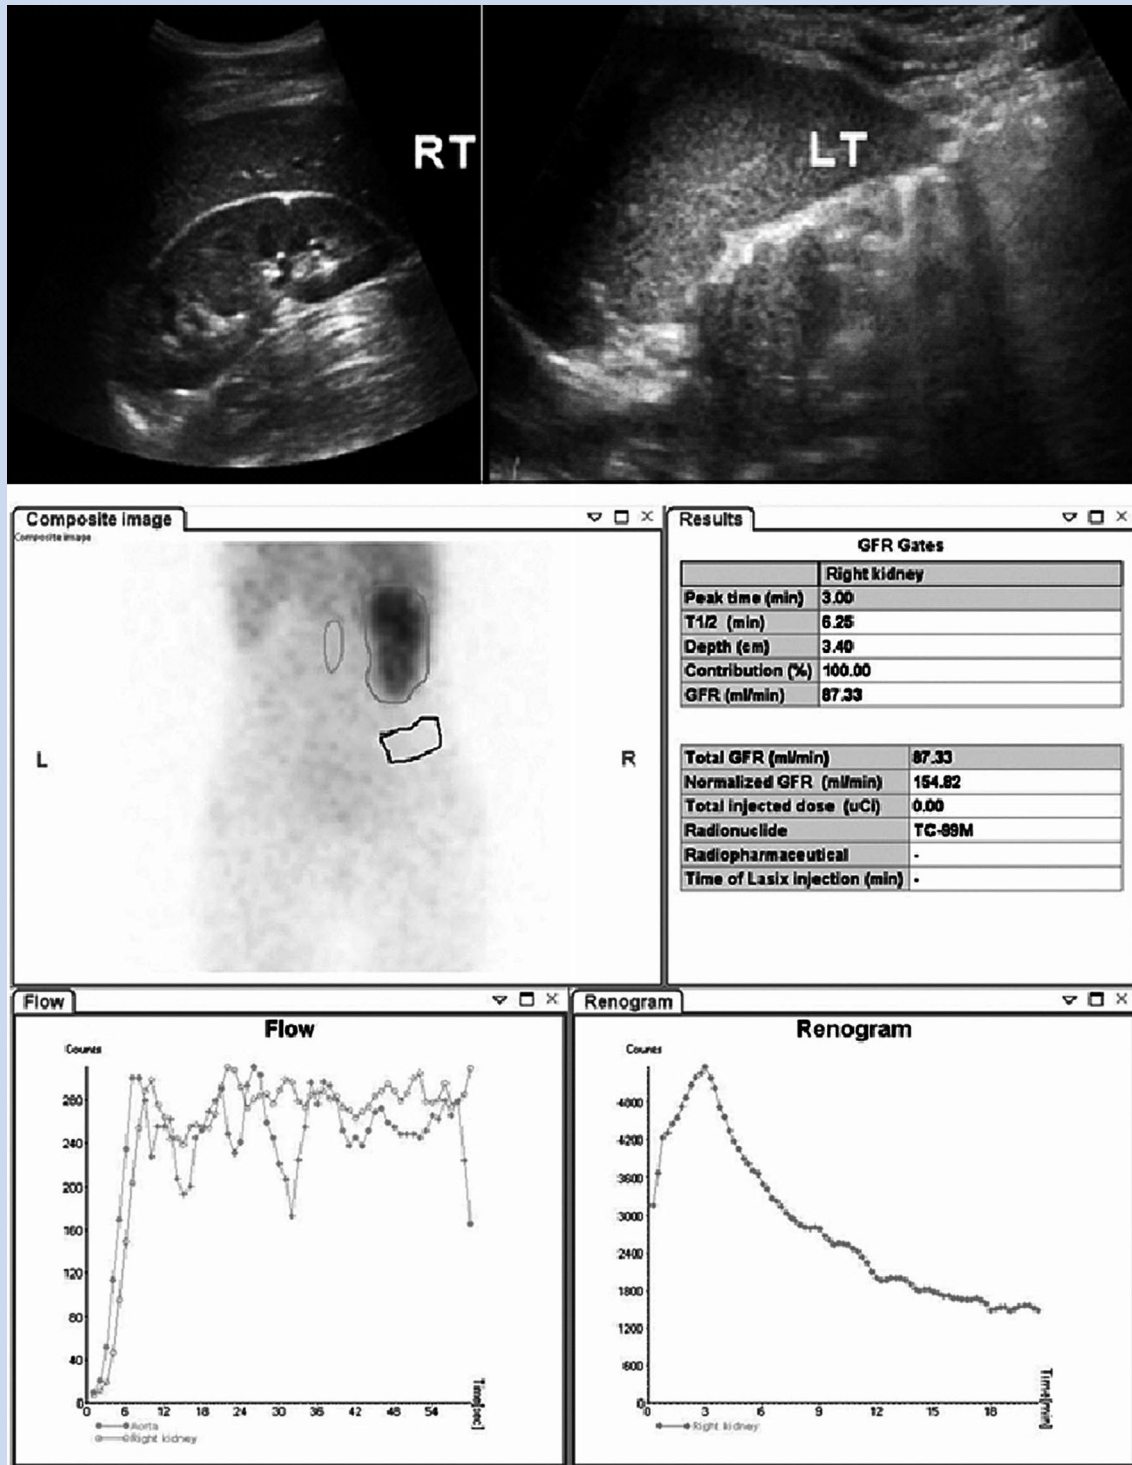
Renal ultrasound and scintigraphy of an 11 years old TS patient with 45,X karyotype and normal serum creatinine. Renal ultrasound revealed normal right kidney and non visualized left kidney. Renal scintigraphy confirmed the absence of the left kidney and provided additional information about the remaining single kidney. It revealed decompensated overall renal function as well as decreased amplitude of the right renogram, which necessitates regular follow up for this patient.
